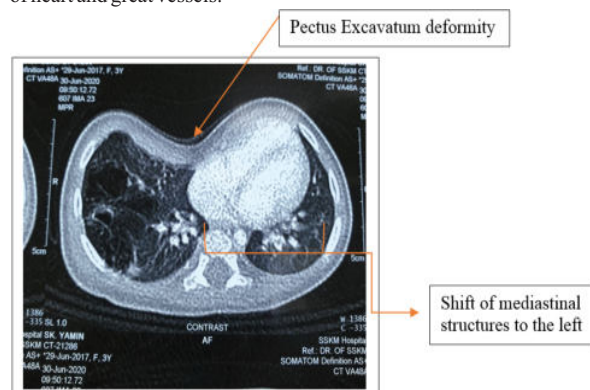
CT scan (Pre-operative): demonstrating the leftward displacement of mediastinal structures secondary to Pectus Excavatum.
